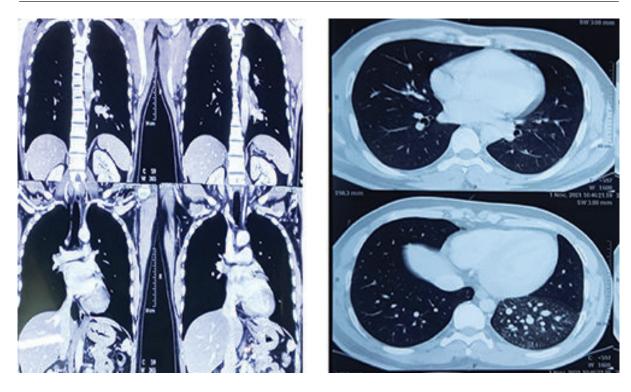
Contrast-enhanced CT scan of chest [coronal view (A), and axial view (B)]
